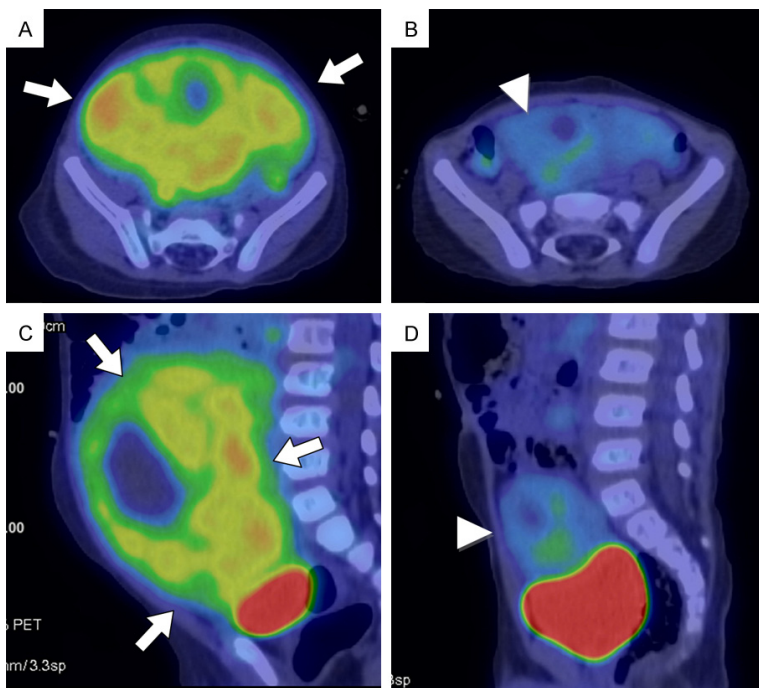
Therapy monitoring in 2-year-old girl with Rhabdomyosarcoma of the urinary bladder with botryoid morphology. Axial (A) and coronal (C) planar [^{18}F] FDG images show a voluminous pelvic mass with high FDG uptake (arrows); partial response (arrowheads) is observed after systemic chemotherapy (B and D).
